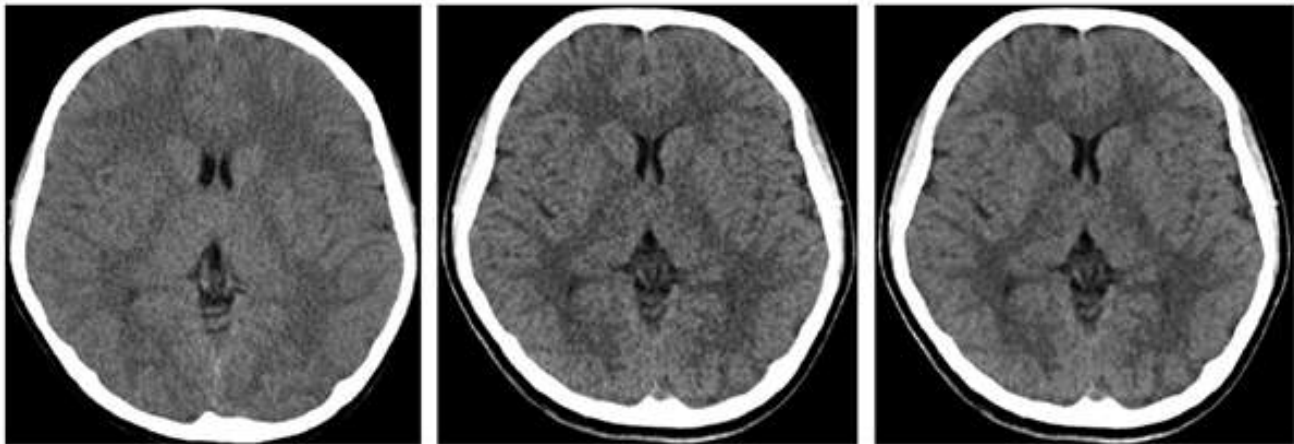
from Nagayama et al. shows evaluation of acute headaches in a girl who underwent two CT examinations, with a 3-year interval. (a) axial CT image acquired at 120 kVp (CTDI vol, 60 mGy) and reconstructed with FBP shows the girl at 12 years old. (b, c) Axial CT images acquired at 100 kVp (30 mGy) and reconstruction with FBP (b) and SAFIRE (c) show the girl at 15 years old. Gray matter to white matter contrast is improved at 100 kVp, because of greater photoelectric effect, whereas the IR technique is used to compensate for increased noise.
